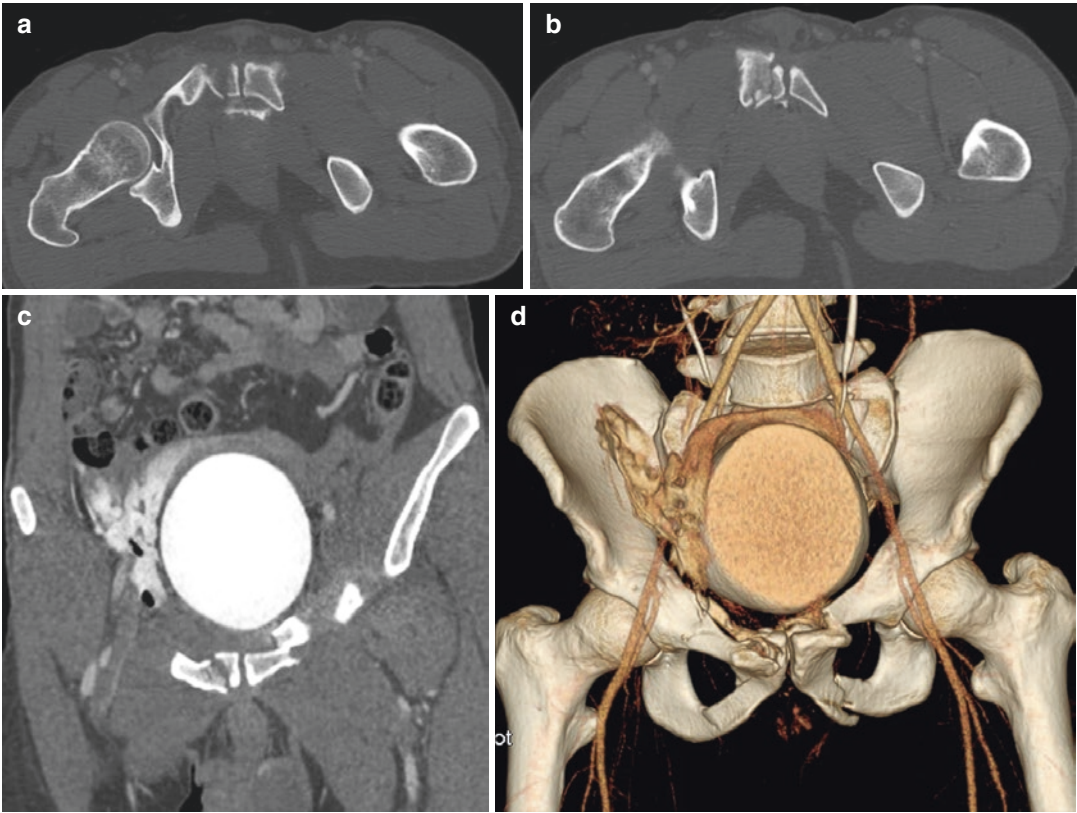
(a–d) Lateral compression fractures (LC), type III unstable. (a, b) CT coronal view shows the fractures of the pubic branches on the impact side and the lateral compression fracture on the opposite side. (c) CT coronal
